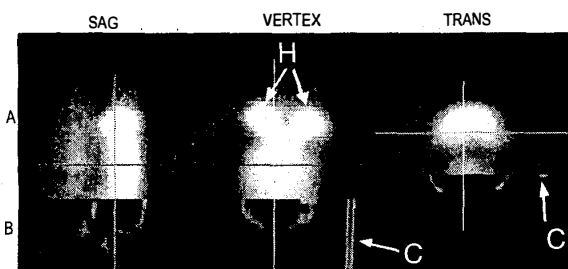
Partial overlays of AIR registered F-18 FDG (A) and CT brain images (B). Note the placement of the PET FDG brain within the CT skull. H=Harderian glands, C=capillary tube.
